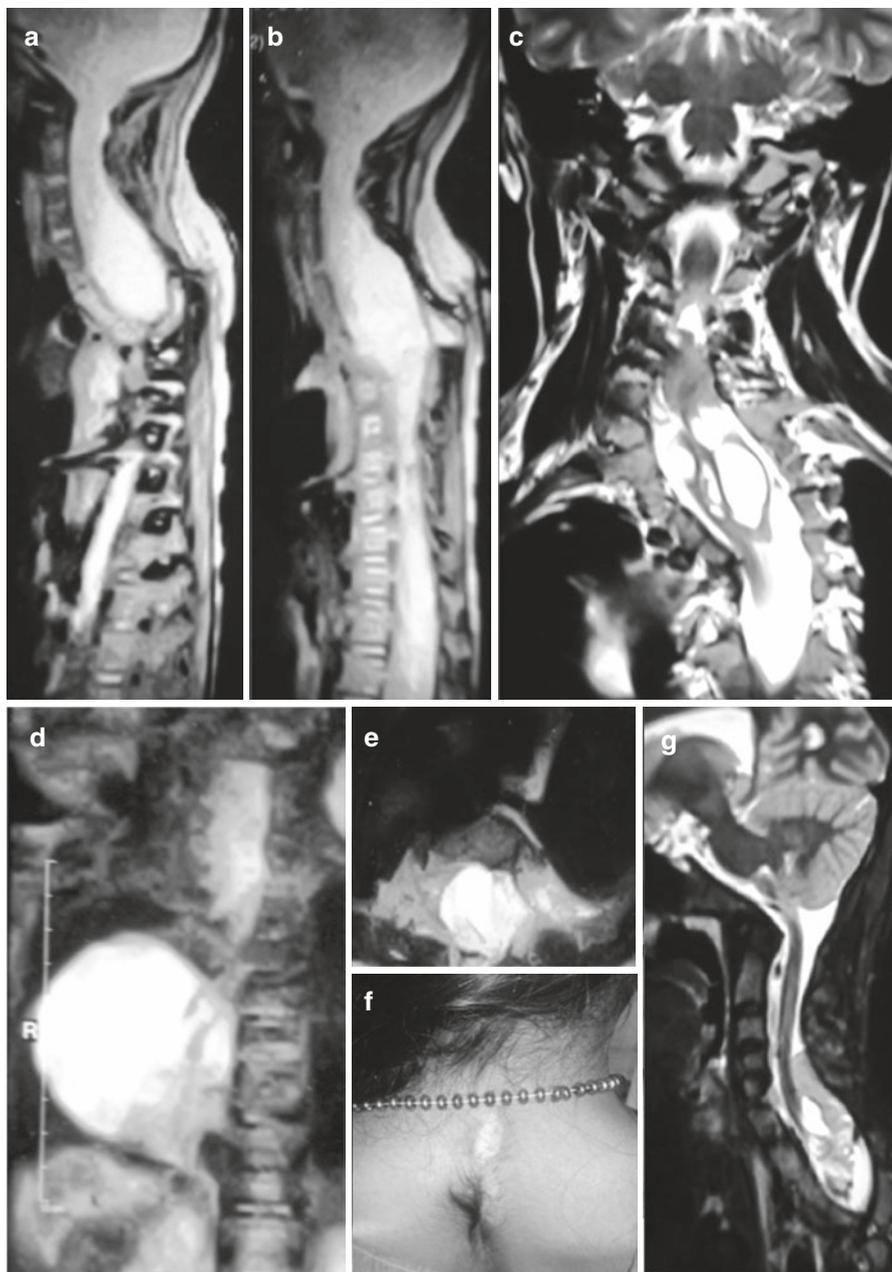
An intradural extramedullary neurenteric cyst at the cervicothoracic region. (a, b) T2 sagittal and (c) T2 coronal image showing the cyst with cervicothoracic scoliosis with split cord malformation and abnormal dilatation of the spinal canal at the same level. (d) T2 coronal MR image of the thoracic spine showing a right-sided posterior mediastinal cyst. (e) T2 axial MR image showing asymmetrical dilatation of the cervical canal and an anteriorly placed neurenteric cyst. (f) Hypertrichosis with spina bifida. (g) T2 sagittal postoperative image shows excision of the cyst. There is persistent syringomyelia. (From Shukla et al. [14]; with permission)
